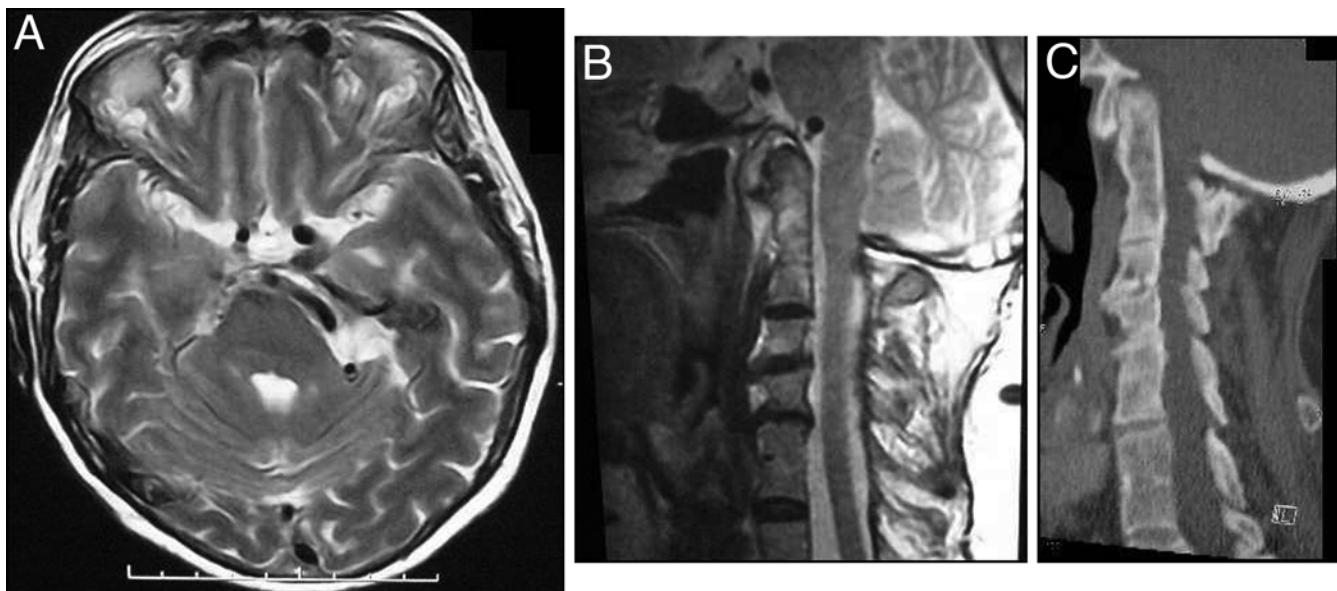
A: Axial T2-weighted MR image showing an ectatic basilar artery that deeply indents into the root entry zone of CN V. B: Sagittal T2-weighted MR image showing marked craniocervical anomaly: an odontoid tip reaching up to the pontomedullary junction. C: Sagittal CT scan showing the abnormal fusions and the curvature of the craniocervical junction. Partial agenesis of the clivus can also be seen.
